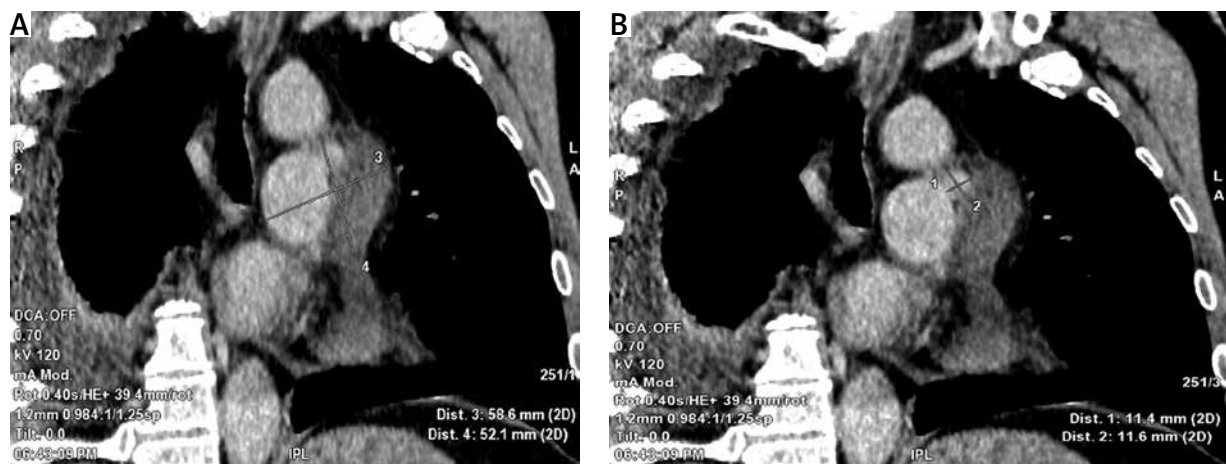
A, B – Computed tomography size of the pseudoaneurysm
